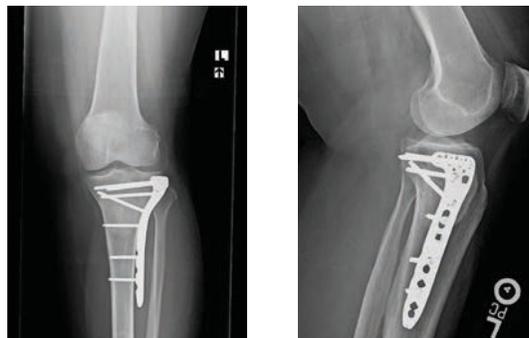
6-month X-rays demonstrating full NanoBone remodeling and no tumor recurrence
